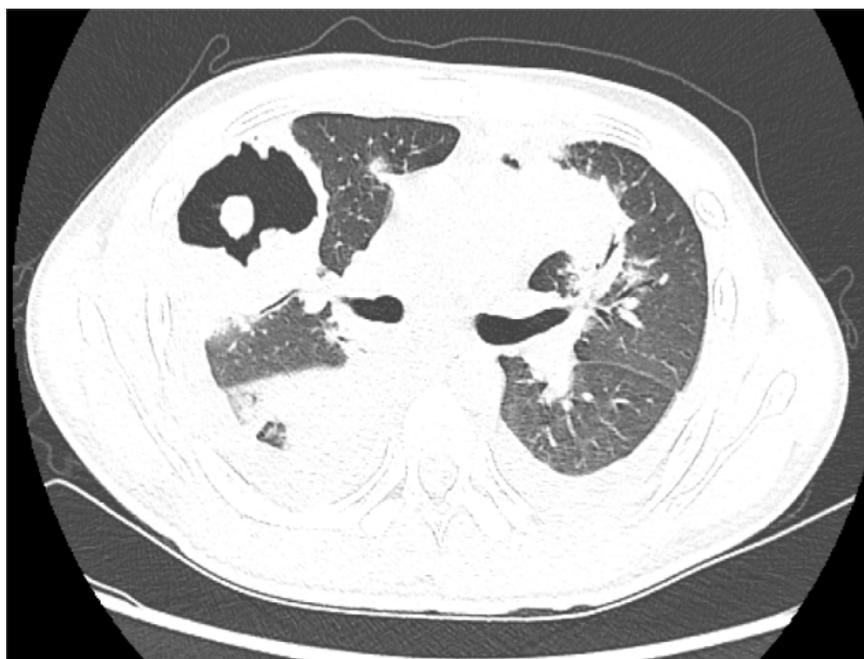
Chest computed tomography on admission. Chest computed tomography on admission showed multiple nodular shadows and cavities ,creating ”an island in the lung” .
